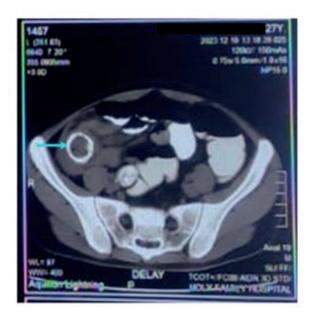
CT Scan of the abdomen showing ringenhancement of the colon post contrast
